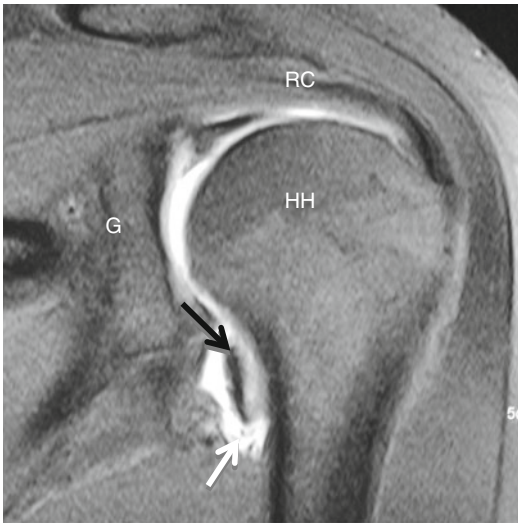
Oblique coronal MR image demonstrating a tear at the humeral attachment of the anterior-inferior glenohumeral ligament (*black arrow*) with distal blood revealing (*white arrow*) “J-sign” (RC rotator cuff, HH humeral head, G glenoid)
